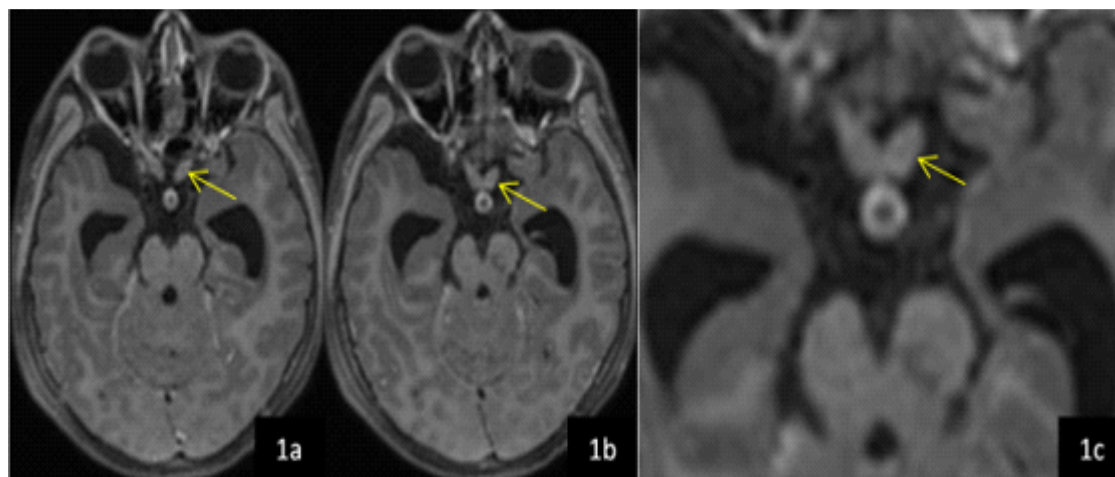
MRI findings in optochiasmatic arachnoiditis. (1a, 1b) Axial contrast-enhanced T1-weighted MRI images showing abnormal enhancement involving the basal/perichiasmatic region (arrows), interpreted in the clinical context as optochiasmatic arachnoiditis. (1c) Magnified view of the perichiasmatic region, demonstrating the enhancing lesion (arrow) in greater detail.
